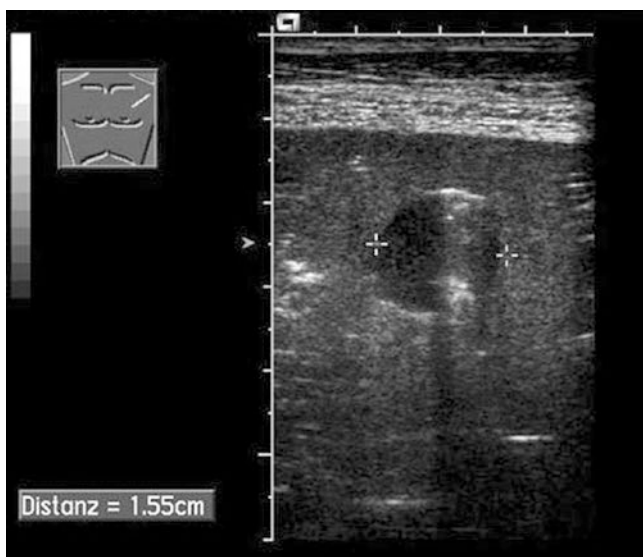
Colligated abscesses with persistent fever. Sonography-guided aspiration showed a surprisingly large number of tubercle bacilli
